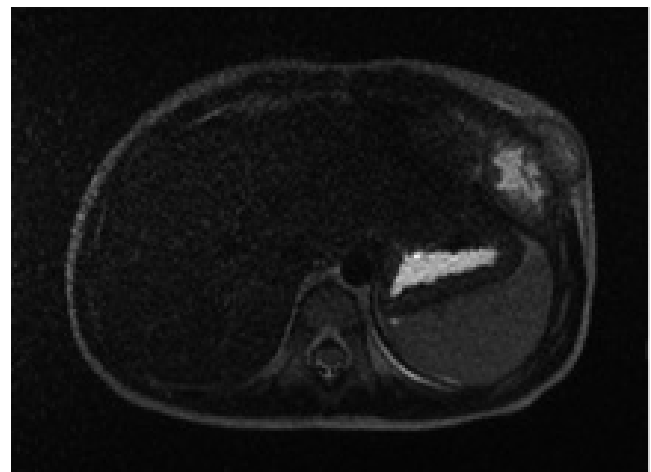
Mass lesion with central hyperintense appearance, cystic-necrotic structure, peripheral hypointense, solid structure, extending into soft tissue in axial T2W MRI examination
